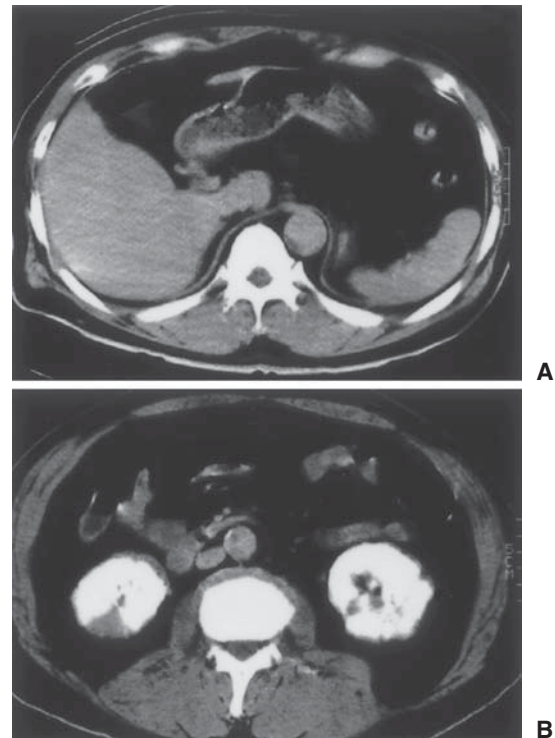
Enhanced computed tomography demonstrated irregularly shaped intraluminal thrombi in the supraceliac (A) and infrarenal (B) abdominal aorta
